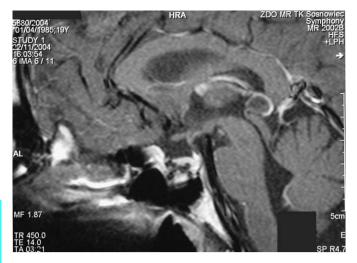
Sagittal T_1 -weighted MRI scan of the empty sella after operation (case 3).
